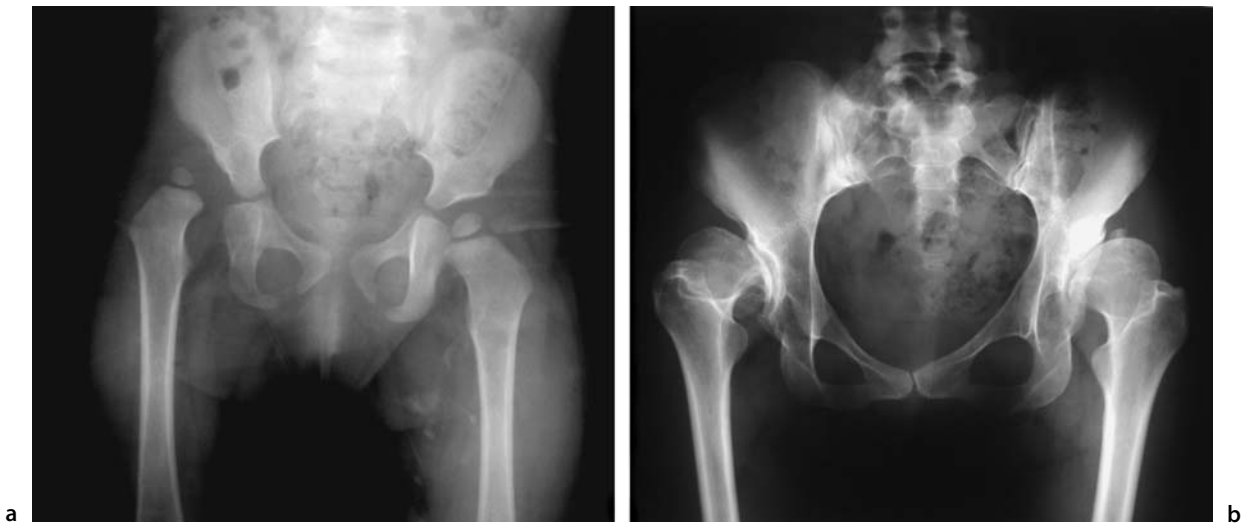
Dislocated hip on radiograph
